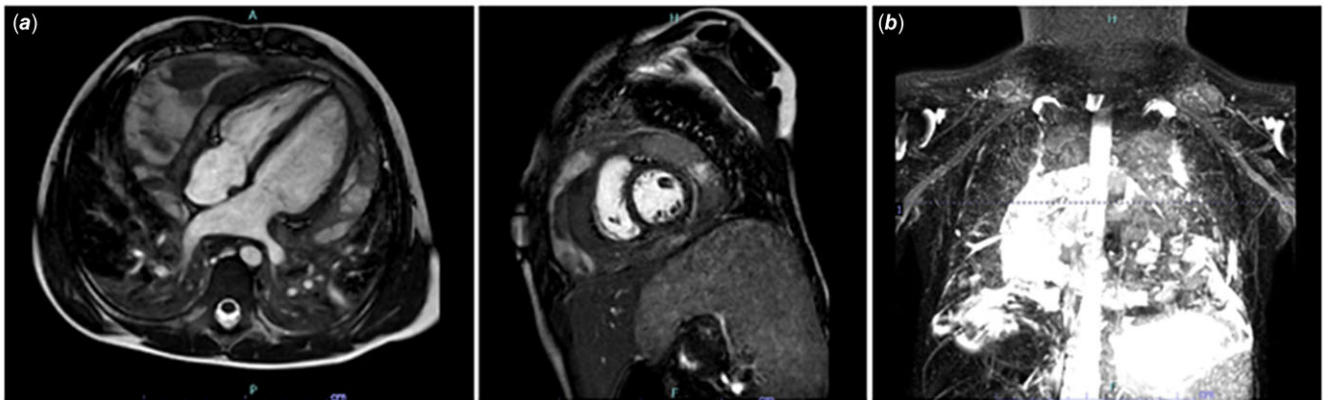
(a) T2 weighted MRI imaging demonstrating a large, circumferential, heterogenous pericardial effusion with extensive loculations. (b) On T2 weighted lymphatic imaging, there is increased signal within the pericardium, consistent with collections of lymphatic fluid. The abdominal lymphatic system is dilated and tortuous beginning at the level of the kidneys with continued tortuosity and dilation through the cisterna chyli through the thoracic duct. There is also hyperintensity in the mediastinum and neck surrounding the great vessels without evidence of compression.
